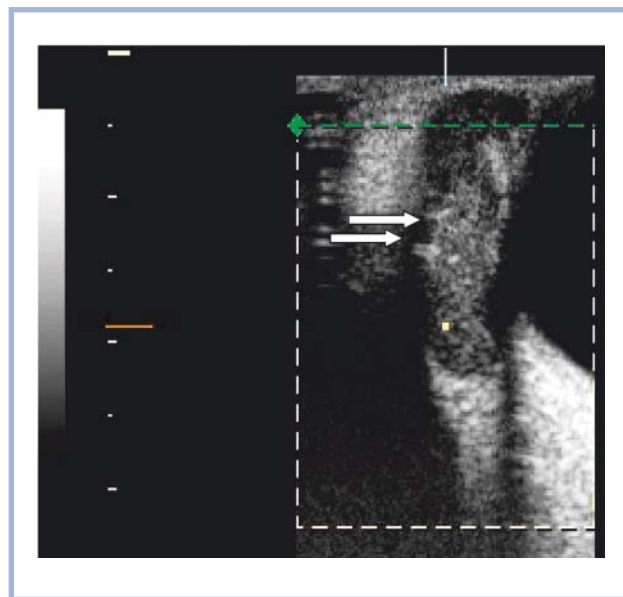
Ultrasonographic image of a lacrimal gland with combined structural changes. Arrows indicate isolated horizontal binary hyperechoic tubular structures. Signs of arteritis.
